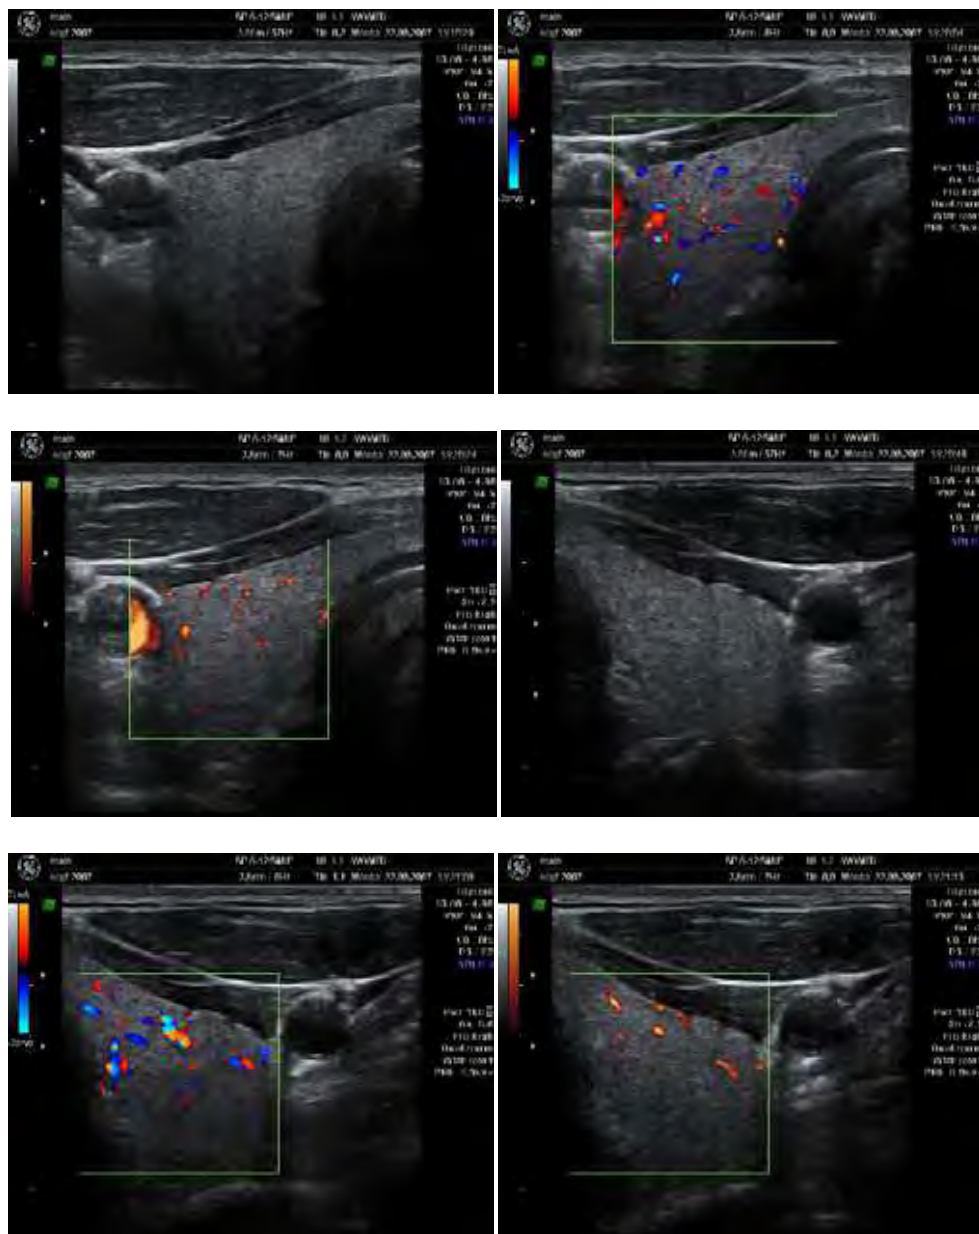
(a-f). Case 3. Both lobes of a normal thyroid shown in gray, color, and power Doppler modus. The VFI value of 0.09 is reflected by the almost complete absence of perfusion signs. Such cases do not require quantitative evaluation of perfusion
